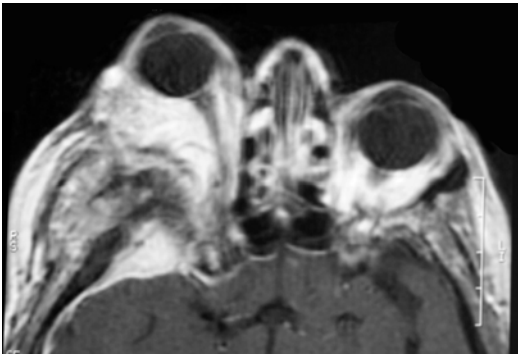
Contrast-enhanced T₁-weighted axial MRI of a sphenoorbital meningioma showing marked enhancement and proptosis of the right orbit (From Cummings [171], Figure 8.20, Page 167. With kind permission of Springer Science + Business Media)
